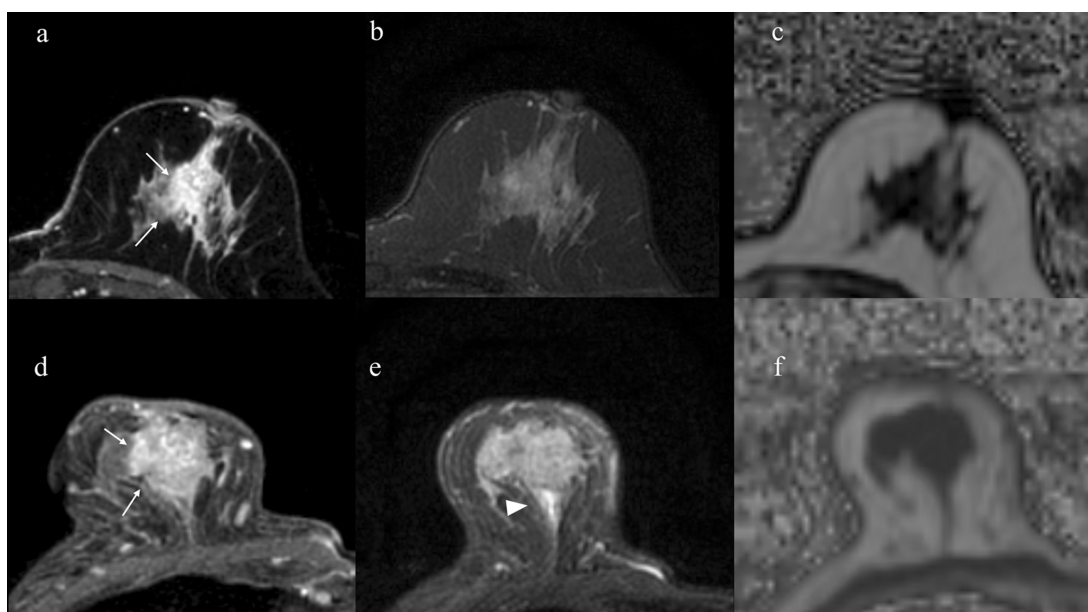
MR images of the cases shown in Fig. 8. (a–c: case without recurrence and LNM, d and f: case with recurrence and LNM). In the case with good prognosis, a high-intensity mass (arrow) in the left breast on axial fat-suppressed post-contrast T1-weighted image (a) and no edema on fat-suppressed T2-weighted image (b) are shown, and the corresponding average peritumoral TFF (91.075) on the fat fraction map (c) is high. In the case with poor prognosis, a high-intensity mass (arrow) in the left breast on axial fat-suppressed post-contrast T1-weighted image (d) and the high signal intensity surrounding the tumor (arrowhead) on fat-suppressed T2-weighted image (e) are shown, and the corresponding average peritumoral TFF (67.875) on the fat fraction map (f) is low. LNM, lymph node metastasis; TFF, tumor fat fraction.
